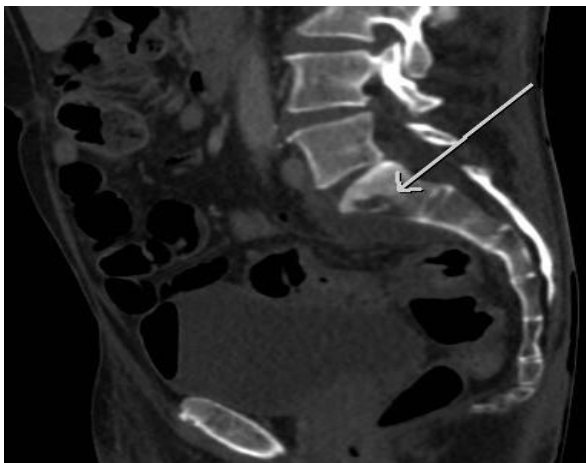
CT showing erosive changes of the S1 vertebra concerning for osteomyelitis.
